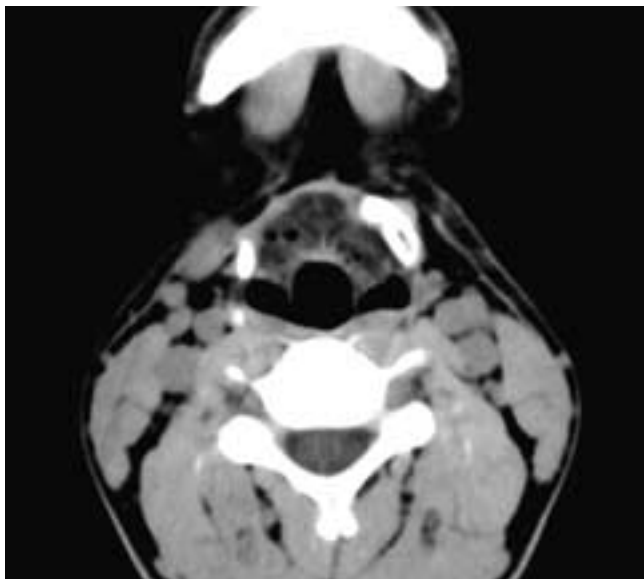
Axial CT scan on a patient who has had a Sistrunk procedure for a thyroglossal duct cyst. The body and a portion of the right greater cornu were resected.
